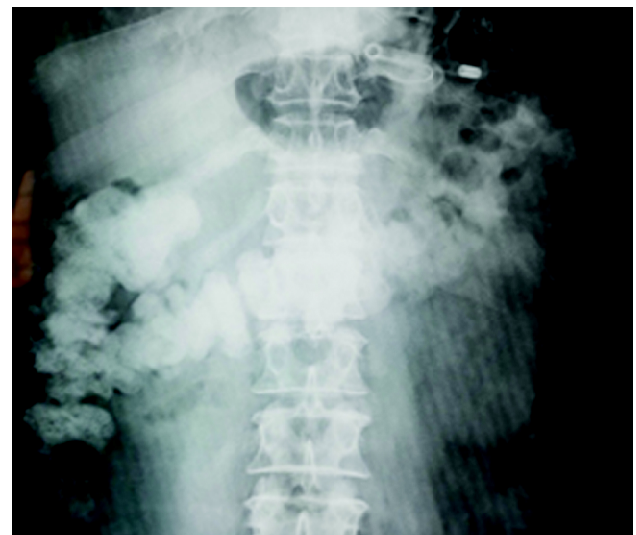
Straight X-ray abdomen, showing colon loaded with stool.
